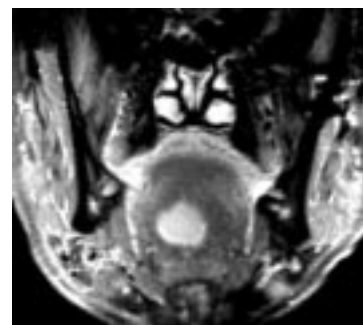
Coronal post-Gd-DTPA SE T1-weighted MR Image
